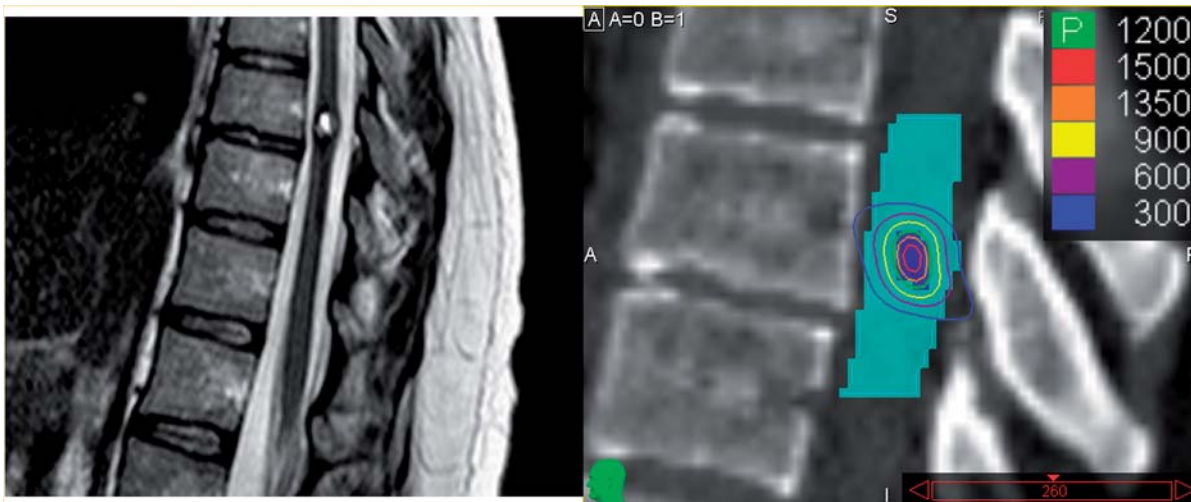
Cavernal angioma of the thoracic cord. Left panel shows a sagittal slice from a T2-weighted MRI; right panel shows a reconstructed sagittal CT slice with an isodose plan, and the PTV (dark blue overlay) and spinal cord (light blue overlay) contoured. Note the internal dose gradient within the PTV. The isodose key is in the top right corner; doses are shown in centigray (cGy), where 1 Gy = 100 cGy.
